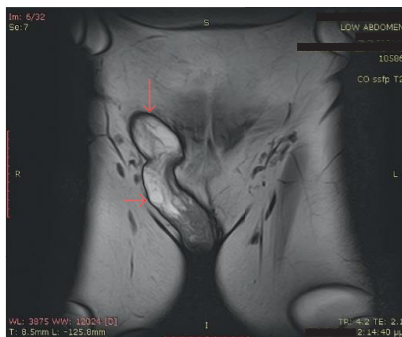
MRI image showing the hernial sac and content
